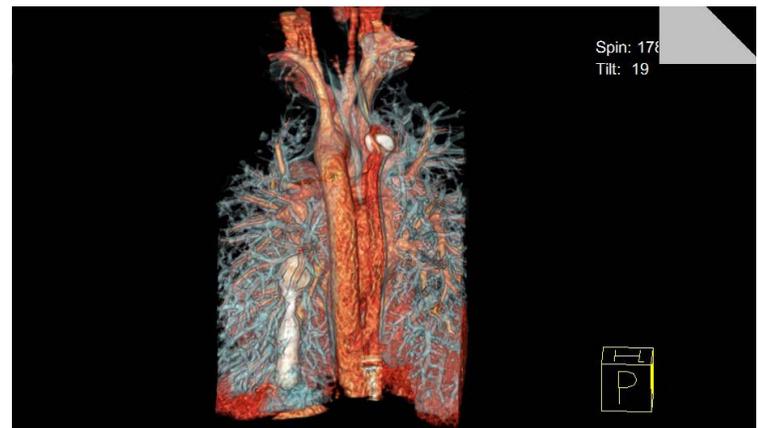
Multi-Slice CT heart and chest PA view showing ASD occlusion device sealing the main feeding artery with PAVM not visualized.
